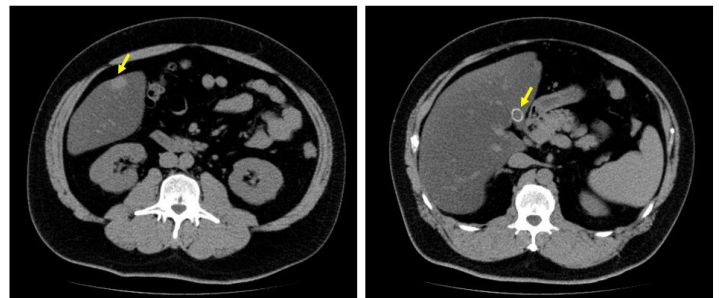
Findings of abdominal CT scan.
